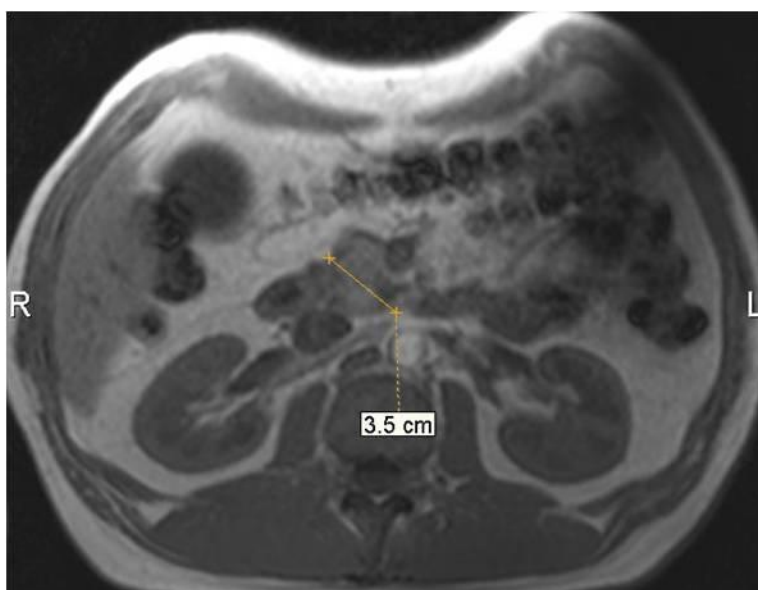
MRI of the patient K. Aug. 24, 2016. Increase in the head of the prostate. MR-sequence T1VI, axial plane of scanning.
